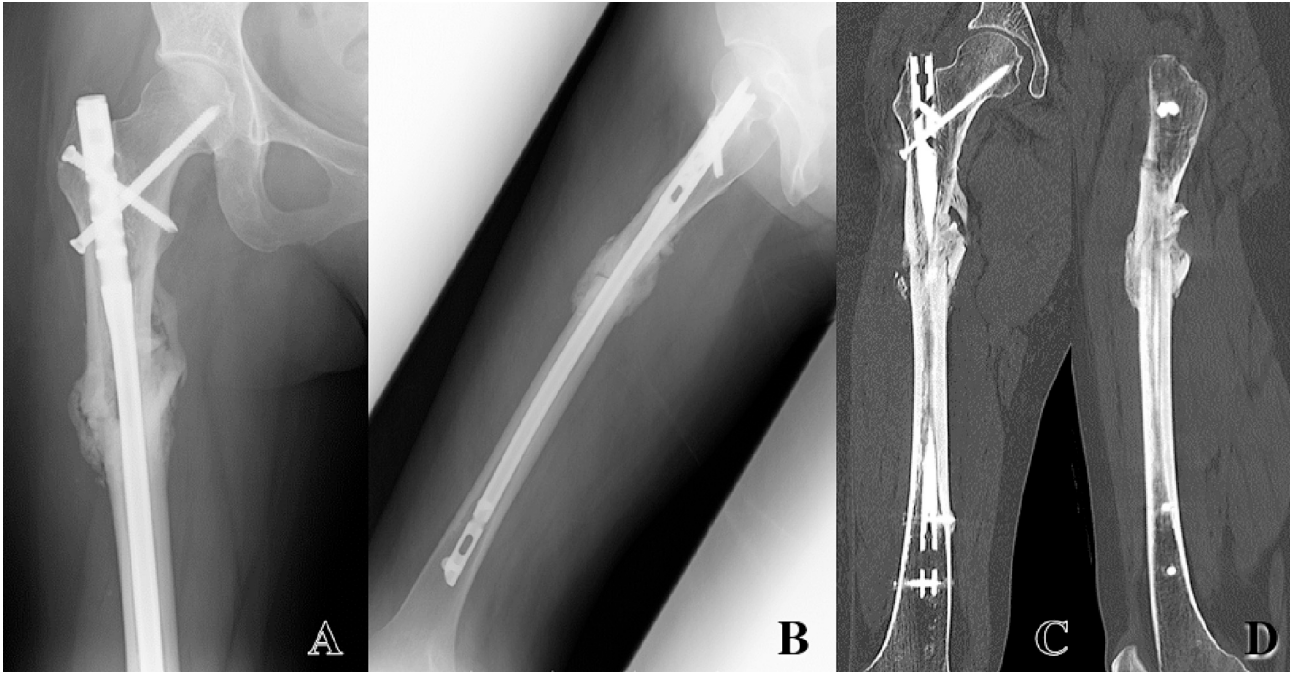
(A) Anteroposterior (AP) and (B) lateral radiographs and (C) coronal and (D) sagittal computed tomography (CT) images taken 6 months after surgery show bone union.
